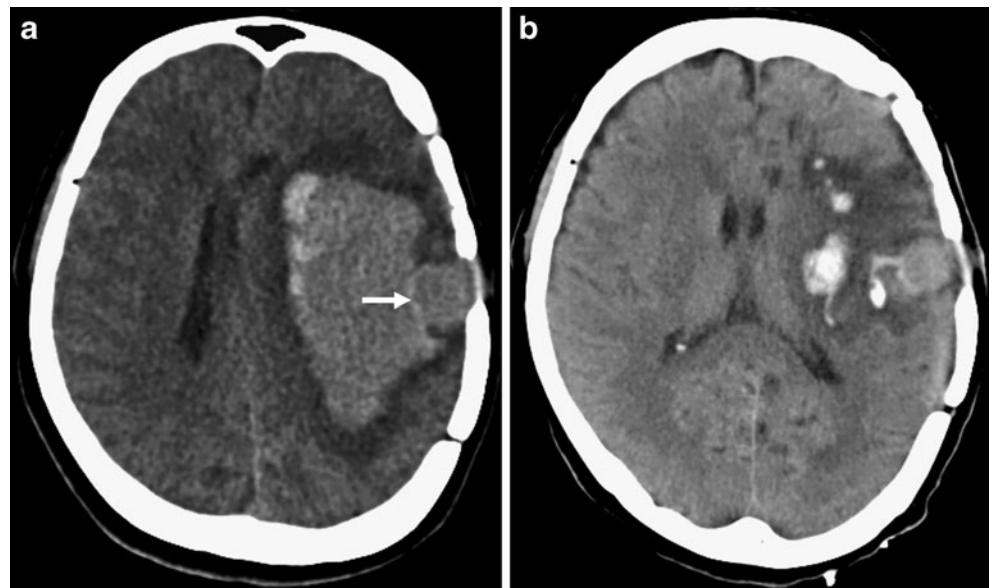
a Cranial CT scans showing a massive ICH in the left frontotemporoparietal region, which is associated with a round, aneurysm-like lesion (*arrow*) that is contiguous to the site of left temporal craniotomy. b Postoperative CT scans obtained 2 days later showing almost complete removal of the hematoma except for the aneurysm-like lesion
